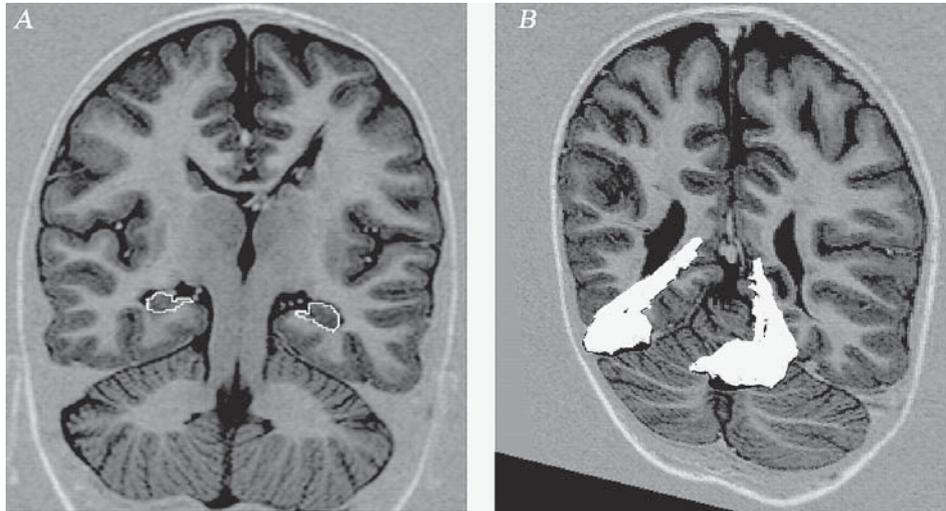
Hippocampal segmentation. A, a coronal inversion recovery MRI scan for an 8-year-old child, with contours of both hippocampi traced manually. B, a coronal inversion recovery MRI scan for the same child, with both hippocampi reconstructed three-dimensionally
